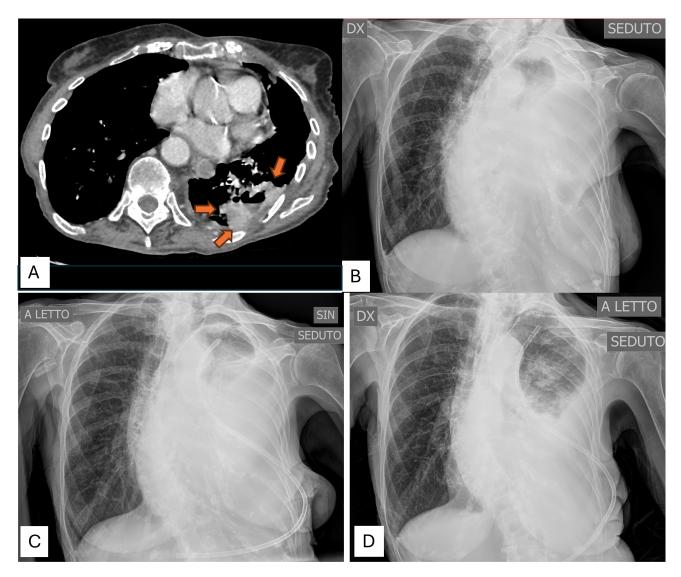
Radiological findings in the management of recurrent pleural effusion. (A) Computed tomography image showing the cavitated lung mass (red arrows). (B) Left recurrent pleural effusion, 20 days after tale slurry. (C) Chest X-ray after indwelling pleural catheter positioning. (D) Chest X-ray at discharge.
